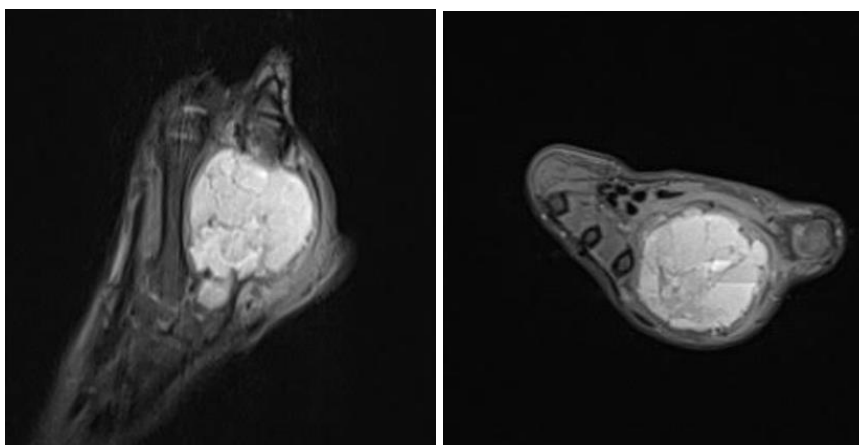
MRI of the right hand, T2/proton density fat-suppressed sequence: multiloculated mass composed of multiple septated cystic cavities with fluid-fluid levels
